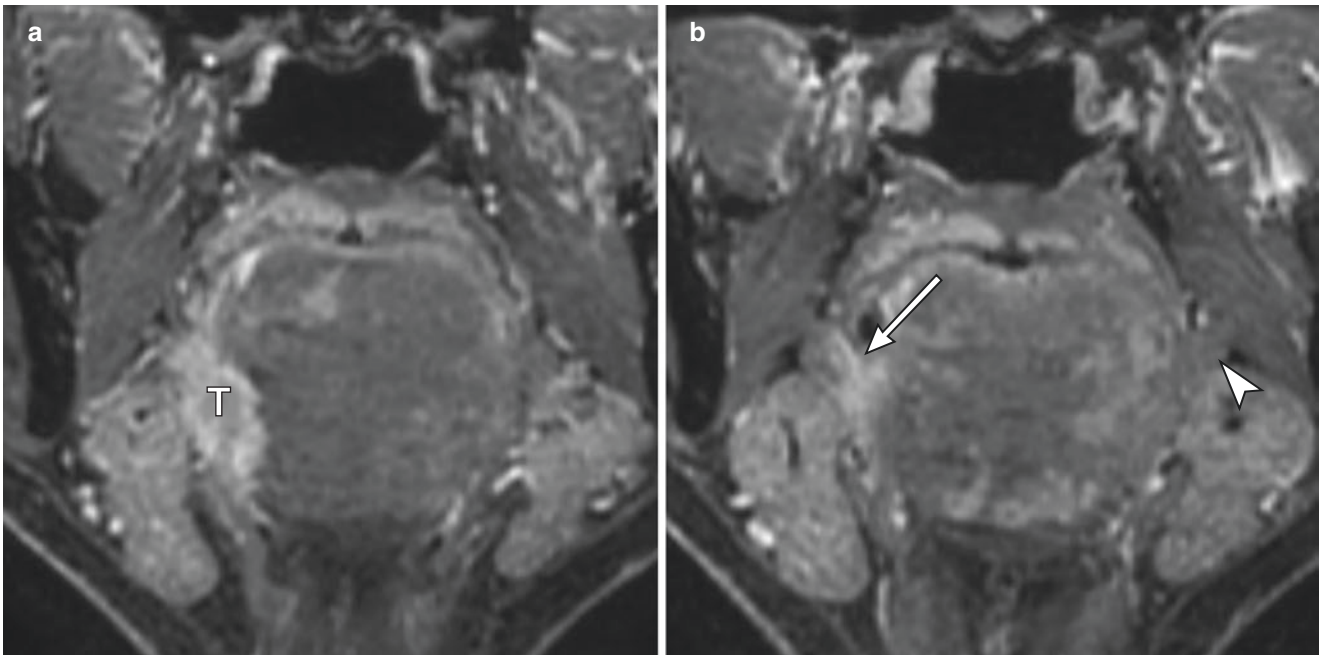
A 65-year-old man with squamous cell carcinoma of the tongue. (a, b) Post-contrast T1-weighted image with fat suppression shows the tongue cancer (T) invading the hyoglossus muscle and spread
